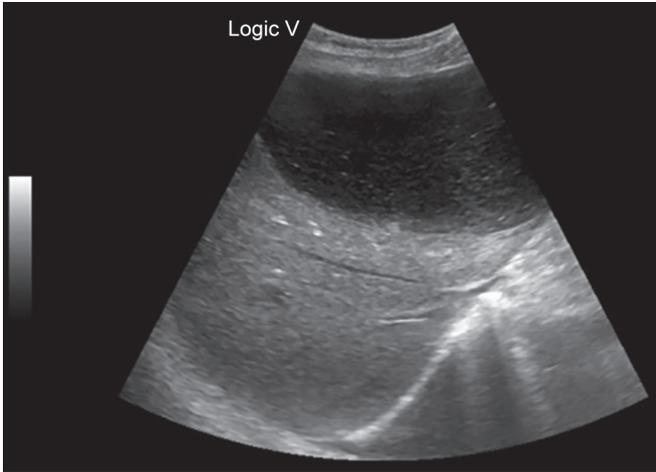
Ultrasound showing large intrahepatic pseudocyst in left lobe of liver
